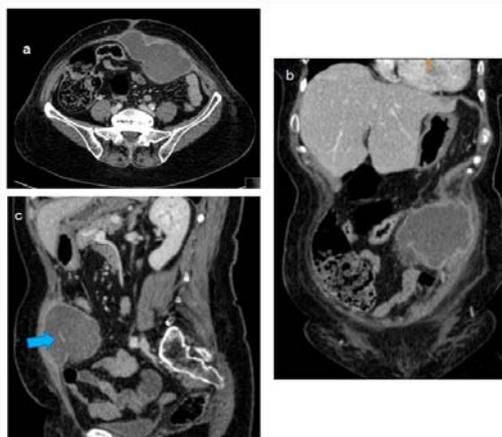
Abdominal enhanced CT revealing a 11 cm x 8 cm x 6 cm collection in the left rectus muscle with fish bone (blue arrow) inside. a. axial view. b. coronal view. c. sagittal view.
